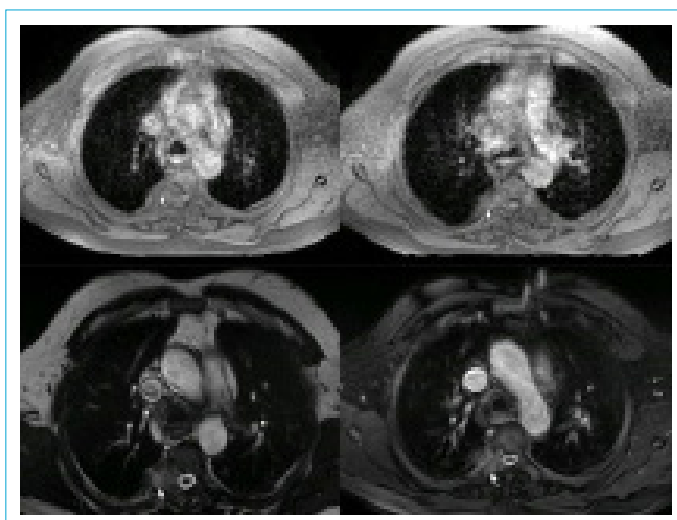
Space occupying, poorly demarcated lesion of approximately 28x26 mm size in the right lateral adjacency to vertebra IV extending to the neural foramen and spinal tract extradural space and causing extension in the neural foramen; mildly hyperintense on T2 axial series, intermediate intensity on T1 axial series; no suppression in fat-suppressed series and marked intense contrast uptake in the post-contrast series on mediastinum MRI.
